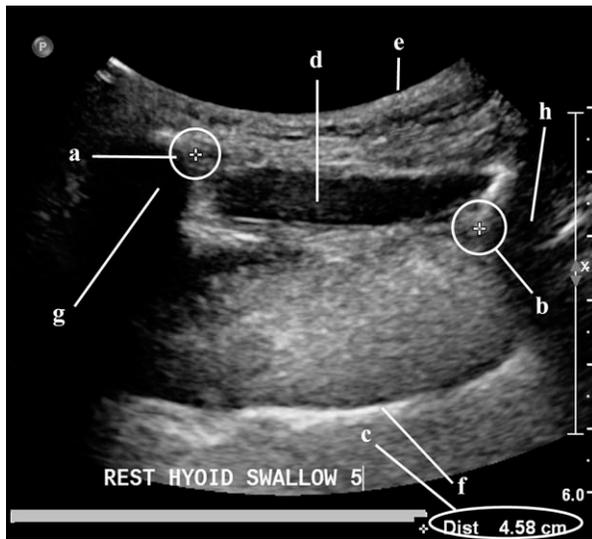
Sonogram of the hyoid/spine of mandible distance at rest. Electronic calipers mark the points at which the distance between mental spine of mandible shadow (A) and the intersection of the hyoid shadow with the geniohyoid muscle (B) is calculated (distance displayed at bottom right of sonogram (C)). Geniohyoid (D), skin surface (E), tongue surface (F), shadow cast by the mental spine of mandible (G), shadow cast by the hyoid bone (H).
